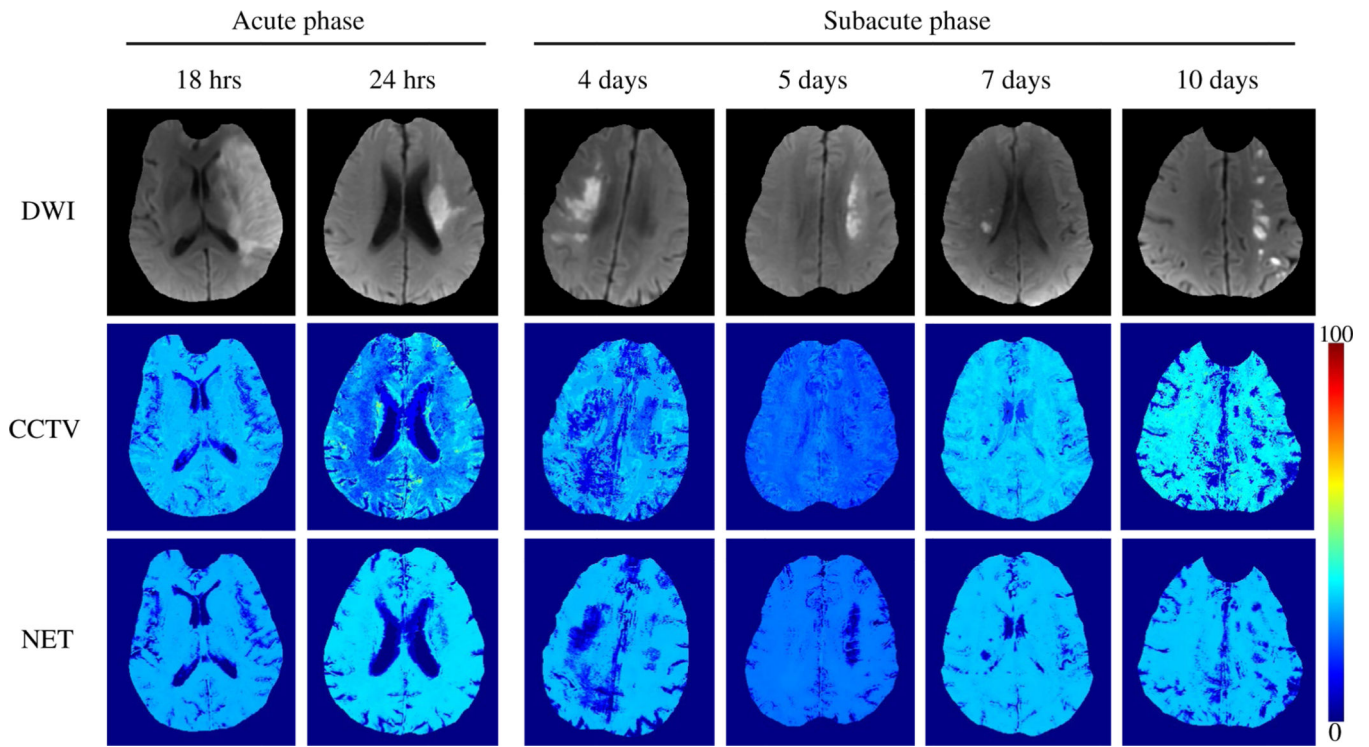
Comparison between the OEFs obtained by QQ-CCTV and QQ-NET in six real ischemic stroke patients (Test Data 2). OEF maps from QQ-NET appear less noisy and have low OEF areas which agree better with DWI-lesions in the subacute phase
